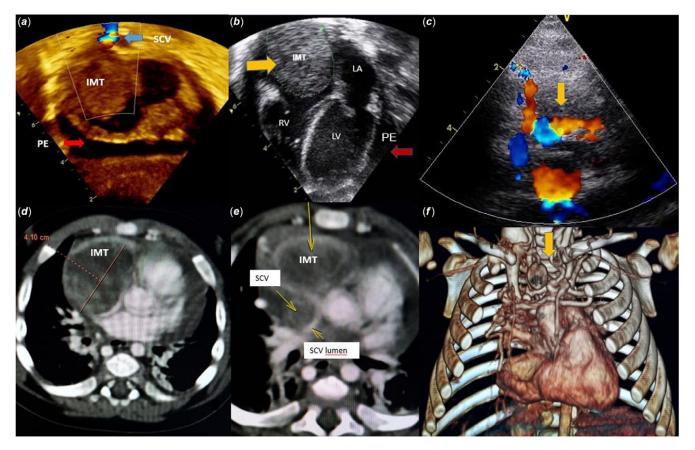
Transthoracic echocardiogram (Echo) showing: A- Color flow Doppler examinaton indicating turbulent jet flow in the SCV (blue arrow), large echogenic mass adhered (IMT) to the roof of the right atrium (RA) and moderate pericardial effusion (PE- red arrow) in the subcostal view; B - IMT (yellow arrow) in the four-chamber view and PE. Note that the echogenic mass spares the tricuspid valve. C - Color flow Doppler by Echo examinaton indicating turbulent jet flow besides entanglement of vessels and collaterals above the RA and in the thymus region (yellow arrow). D - Axial slices on chest angiotomography showing the huge tumor mass in the RA (4.1 cm); E- SCV almost completely occluded, with only a thin line of contrast in the lumen (SCV- RA). F - The same findings detected by Echo in C, now in the coronal reconstruction by tomography. SCV: superior caval vein; IMT: inflammatory myofibroblastic tumor ; LA : left atrium; RV : right ventricle; LV : left ventricle.
